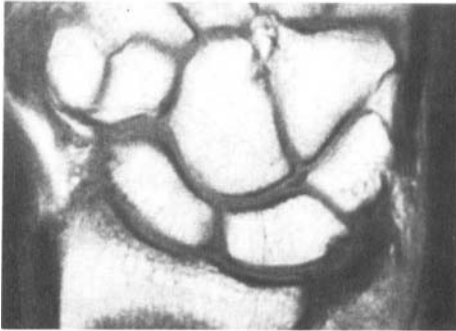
Case 19. Pre- and postoperative MRI in a patient with Kienböck's disease treated by radial wedge osteotomy.
